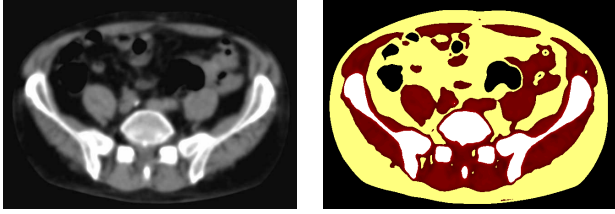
Left: Axial view of an original CT image. Right: The tissue segmented (I_{ct}^s) image where air, fat, muscle and bone regions are colored by black, yellow, red and white respectively.
